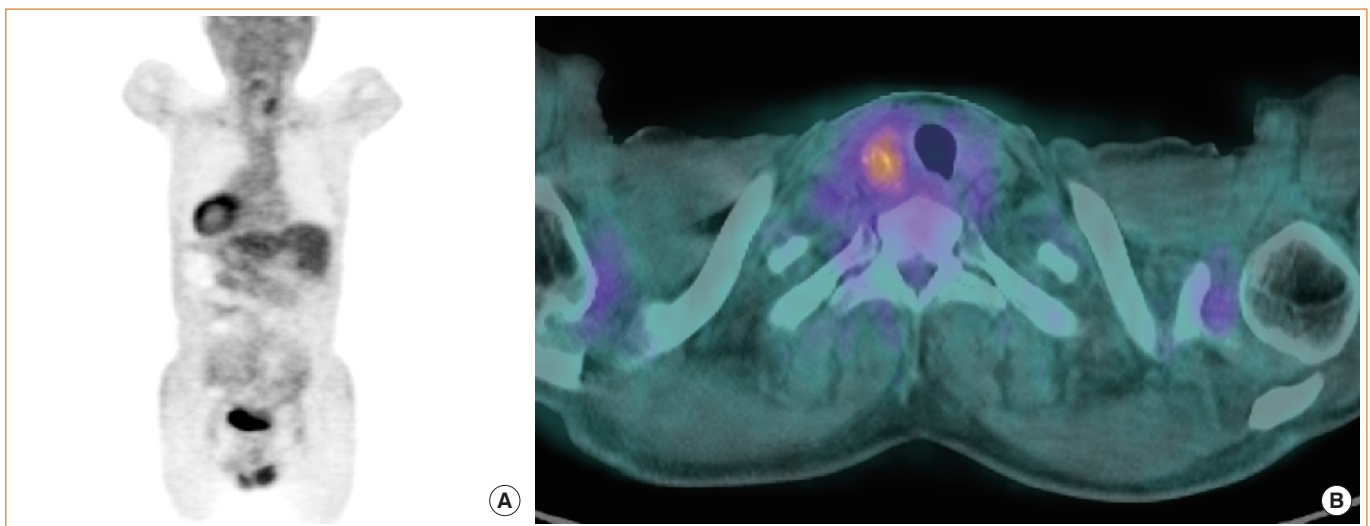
A 60-year-old man with underlying sigmoid colon cancer. (A) A focal fluorodeoxyglucose-avid lesion with calcification was incidentally detected in the right lobe of the thyroid (posterior-anterior view). (B) Fusion axial positron emission tomography/computed tomography image showing a hypermetabolic lesion and calcification in the right lobe of the thyroid gland (maximal standardized uptake value=2.6).
